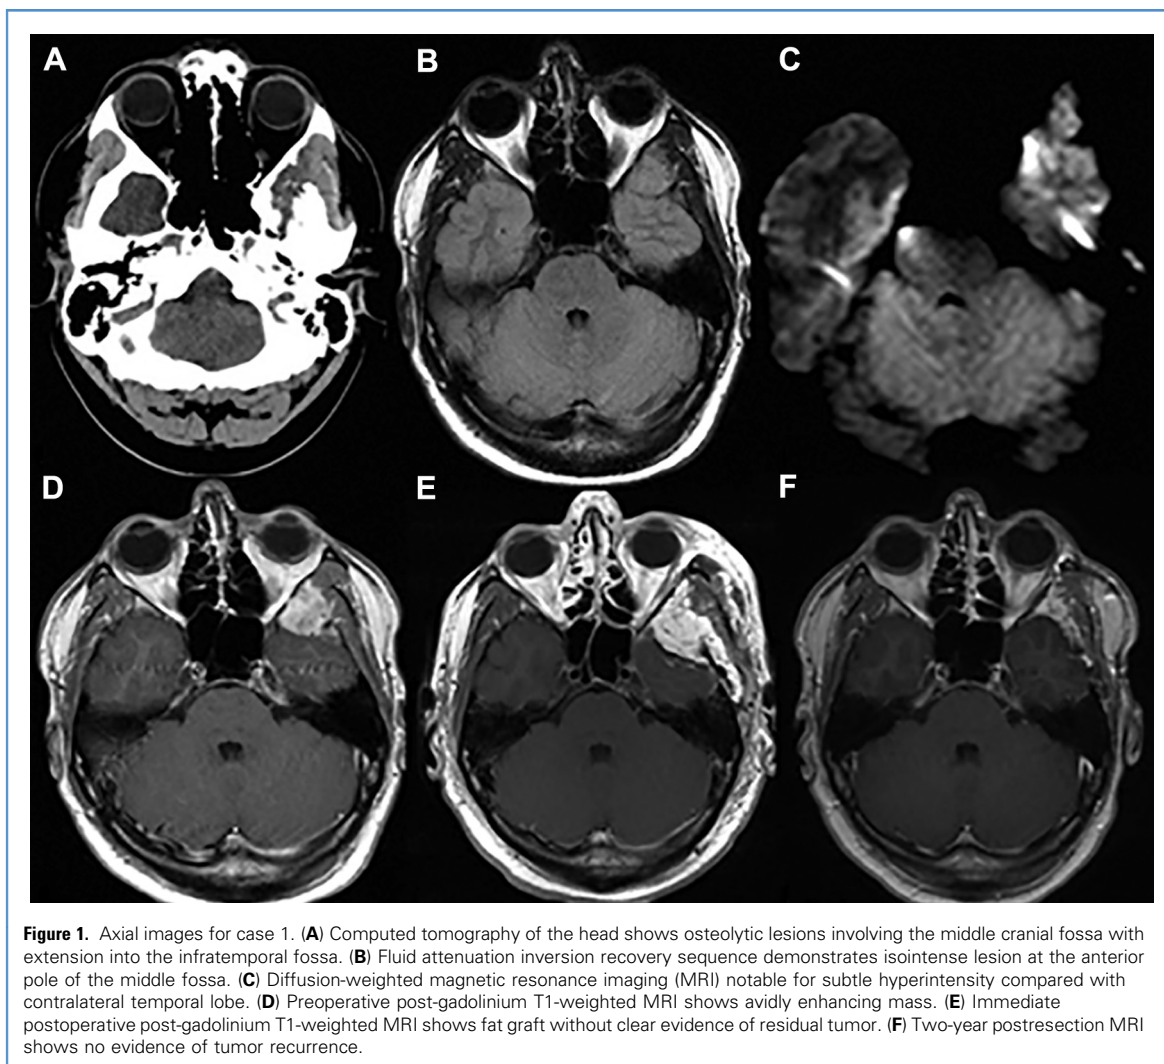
Axial images for case 1. (A) Computed tomography of the head shows osteolytic lesions involving the middle cranial fossa with extension into the infratemporal fossa. (B) Fluid attenuation inversion recovery sequence demonstrates isointense lesion at the anterior pole of the middle fossa. (C) Diffusion-weighted magnetic resonance imaging (MRI) notable for subtle hyperintensity compared with contralateral temporal lobe. (D) Preoperative post-gadolinium T1-weighted MRI shows avidly enhancing mass. (E) Immediate postoperative post-gadolinium T1-weighted MRI shows fat graft without clear evidence of residual tumor. (F) Two-year postresection MRI shows no evidence of tumor recurrence.
